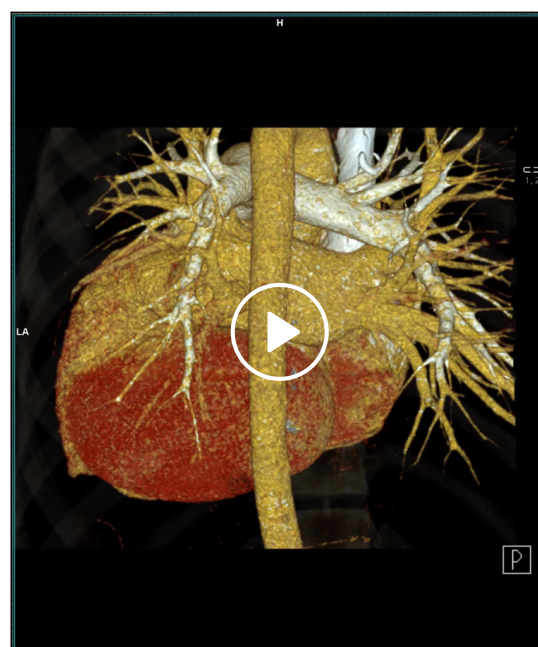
(A, B) Volume-rendered images demonstrate a dilated and tortuous right coronary artery (RCA) along its entire course. (C–E) Multiplanar reconstructions of computed tomography angiography depict a fistulous connection (arrowhead) between the distal RCA and the coronary sinus (CS). Also present is stenosis of the CS ostium (thick white arrow in E) with aneurysmal dilatation of the CS. (F) Volume-rendered image shows the dilated CS displacing the heart cranially. LV: left ventricle; RA: right atrium; RV: right ventricle
